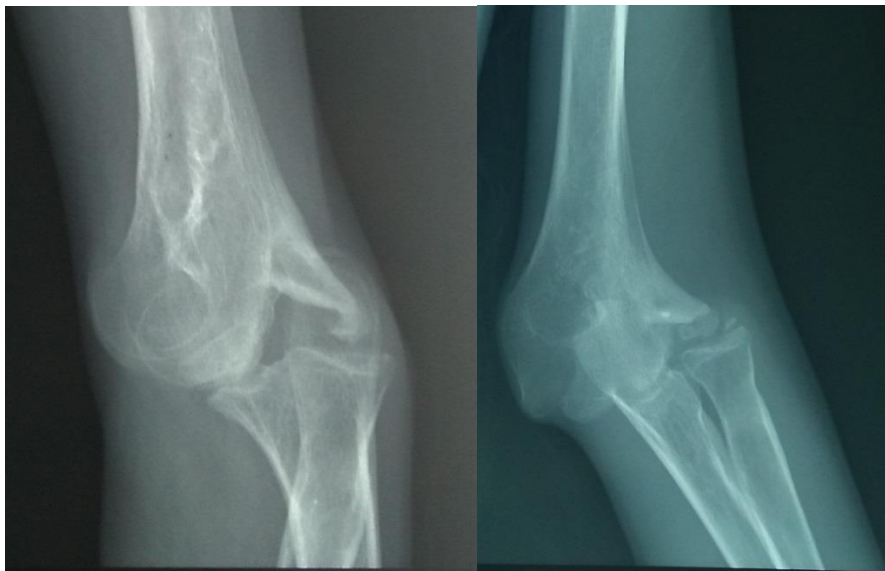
Elbow x-ray: posterolateral elbow dislocation with heterotopic calcifications
